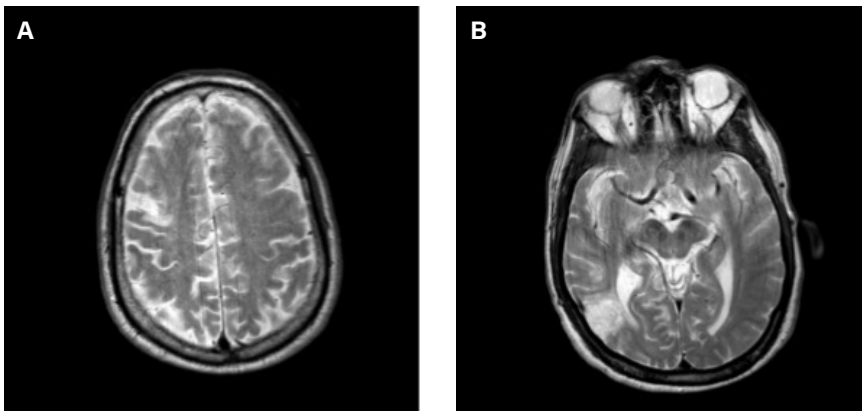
Axial T2-weighted images confirming chronic infarcts in the right frontal (A) and temporo-occipital (B) lobes.
